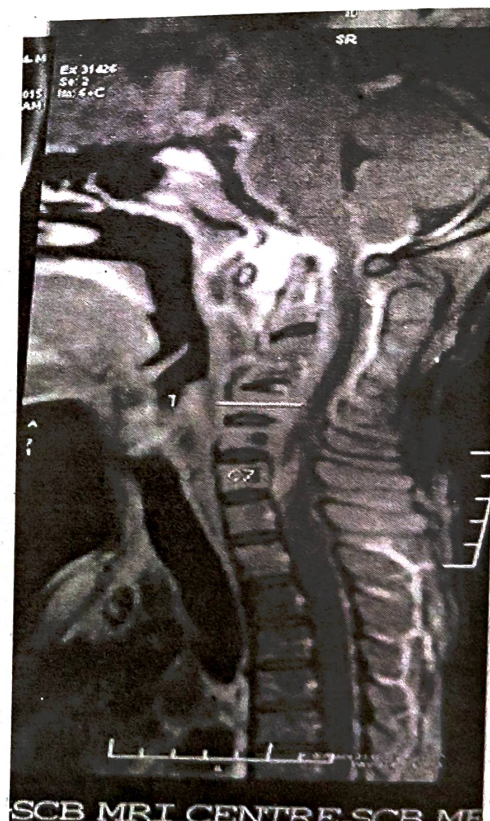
Sagittal section of MRI Spine showing marrow edema from C3 to C7 an discitis and variable enhancement of vertebral bodies.
